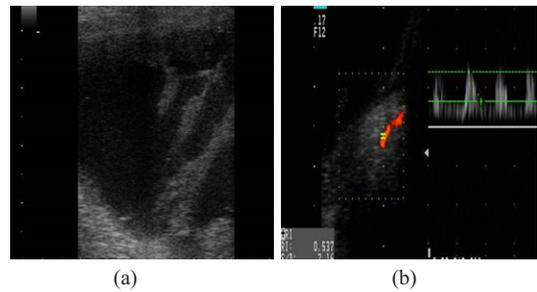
USG image showing thick synovium with joint effusion in knee joint of a patient (a). Low resistance type flow seen on spectral Doppler in same patient within the thick synovium (b).
